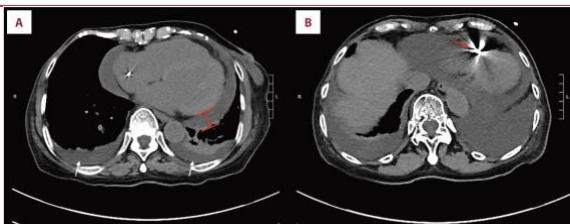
Chest CT showing significant circumferential pericardial effusion and bilateral pleural effusions (A) with right ventricular pacemaker lead tip possibly in pericardial space (red arrow - B).
